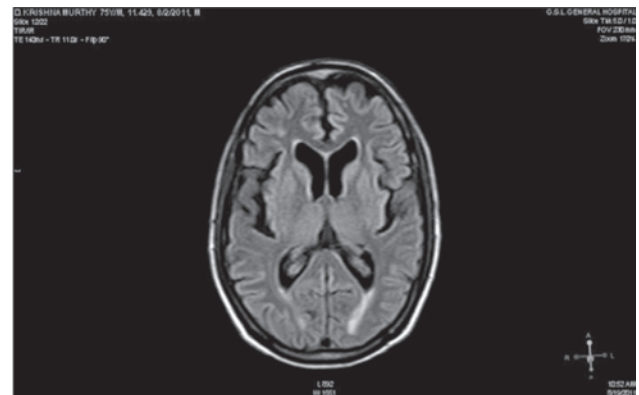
T2 FLAIR axial images taken 3 weeks after the initial presentation showing almost complete resolution of white matter lesions.
